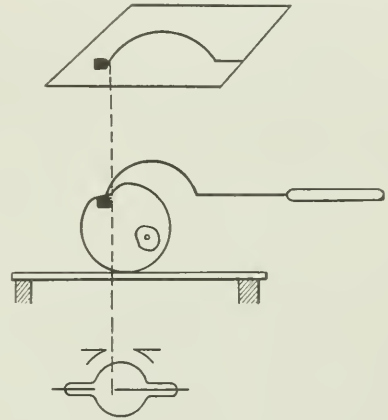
MOBILIZATION OF A SUPERFICIAL PROJECTILE BY THE INDICATOR HELD IN THE HAND OF THE ROENTGENOLOGIST.
